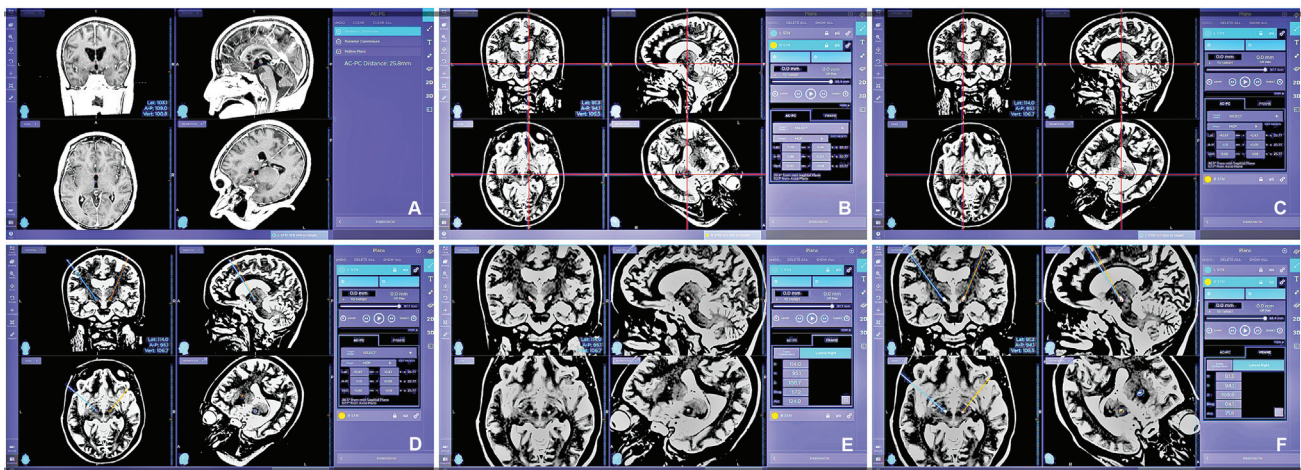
(A) Magnetic Resonance imaging (MRI)-T1 weighted image (T1WI) showing anterior commissure (AC) and posterior commissure (PC). Distance between the AC and PC: 25.8 mm; midline set using Medtronic - Stealth Station™ S8 - DBS software. (B, C) MRI-T2 weighted image (T2WI) showing the location of the subthalamic nucleus (STN) and red nucleus; using the direct/indirect targeting method, the desired target point at the dorsolateral part of STN was selected. (D) MRI-T2WI revealing bilateral STN targeting points; (E, F) MRI-CT fusion images (using Medtronic - Stealth Station™ S8 - DBS navigation software) to check the location of the leads and trajectory post-operatively.
